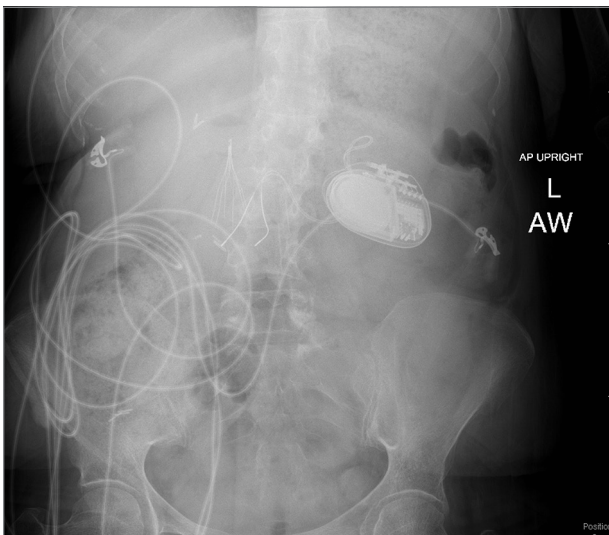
Abdominal radiograph documenting migration of a lead in a patient with recurrent symptoms and an abnormal impedance value.
